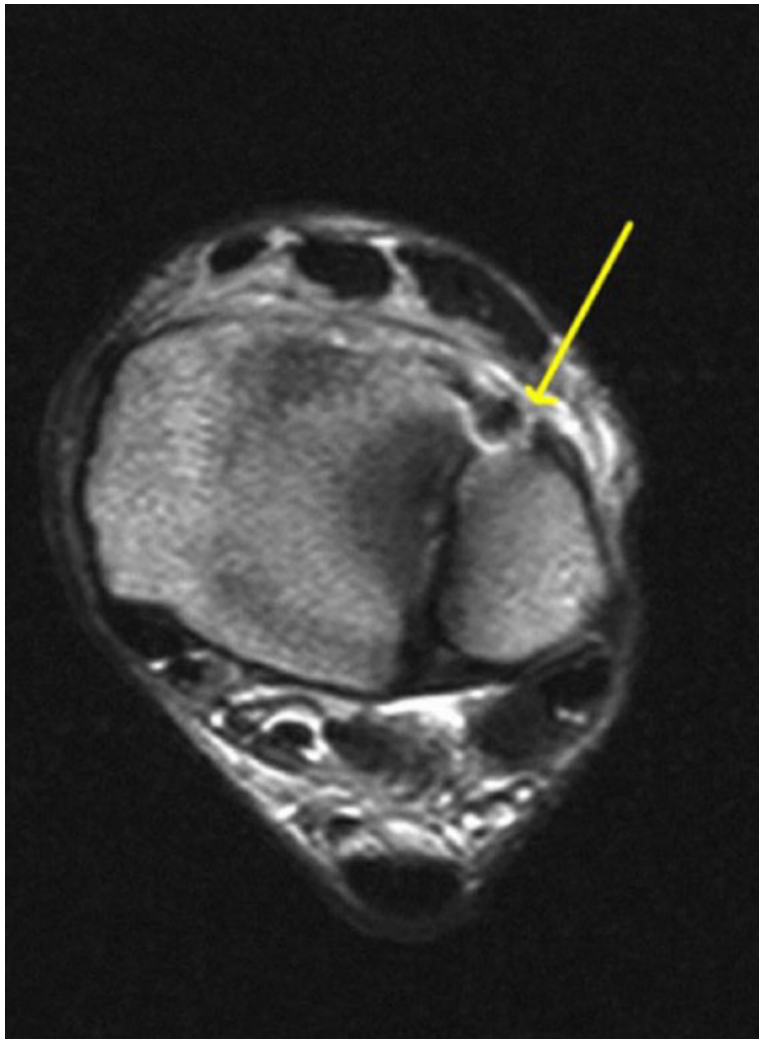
Magnetic resonance image of an elite-level athlete revealing anterior syndesmotomous disruption.
